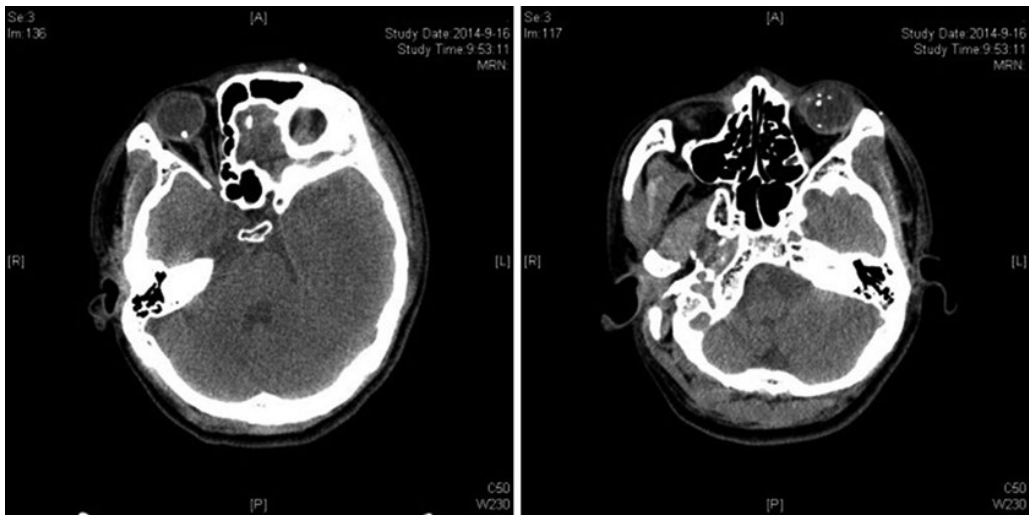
Brain MRI shows: Hyper-reflective in the eyeball of both eyes.
